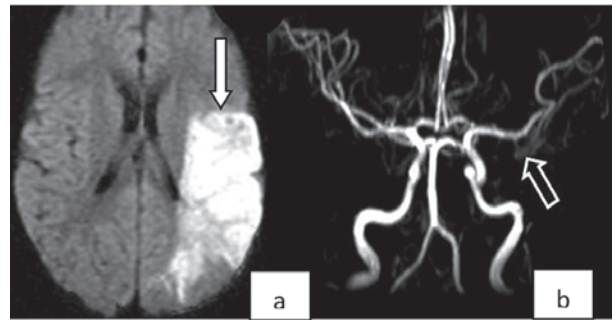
a & b. Axial DWI showing acute infarct in the left parietal region and MR Angiography showing focal irregularity of left middle cerebral artery
